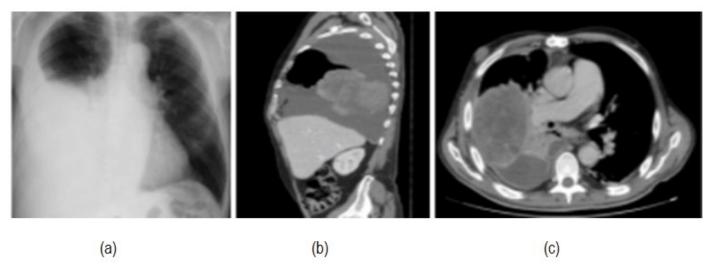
(a) Posteroanterior chest X-ray with homogeneous hypotransparency on the lower two thirds of the right hemithorax, (b) Thoracic Computed Tomography scan reconstructed in the sagittal projection; (c) Thoracic Computed Tomography scan in the axial projection with mediastinal deviation, mediastinal adenomegaly, pleural effusion and a well-circumscribed mass.
